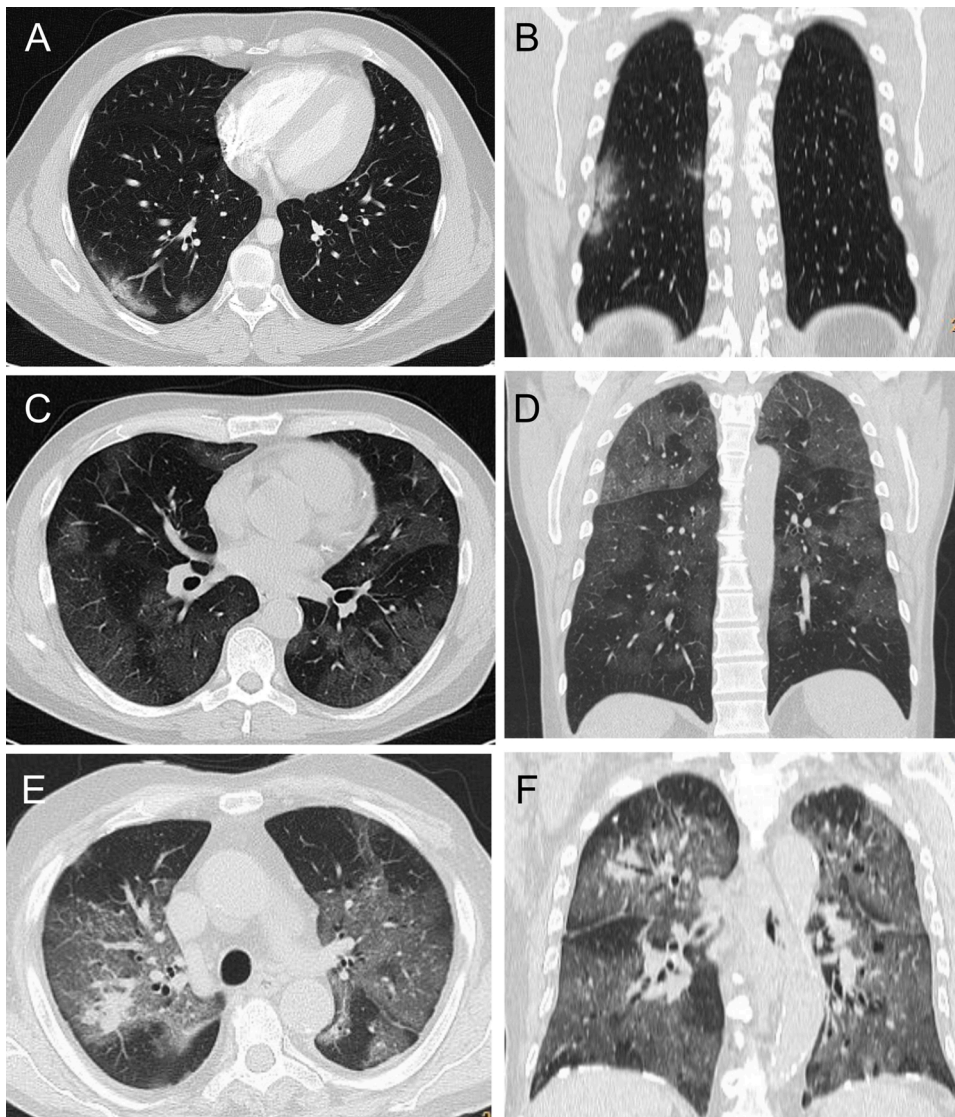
Examples of CT images from patients with Covid-19 pneumonia. Axial image and coronal reconstruction in A), B): a patient showing minimal involvement, peripheral ground-glass opacities exclusively in the right lower lobe, PI score 1, PC score A. C), D): a patient with severe involvement, showing bilateral wide areas of ground-glass opacities, PI score 14, PC score A. E), F): a patient with massive lung involvement, showing near total extension of the pneumonia, and only mild consolidation in the right upper lobe, PI score 18, PC score B.
